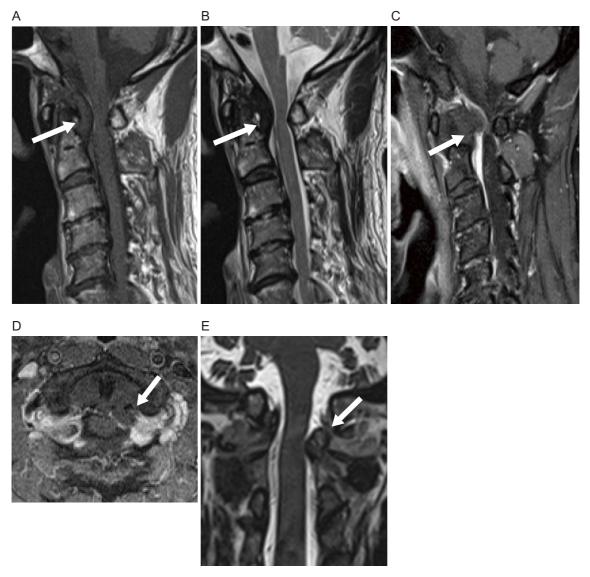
Preoperative magnetic resonance imaging. (A) Retro-odontoid pseudotumor is iso-intense on T1-weighted sagittal image (*arrow*), (B) Retro-odontoid pseudotumor is hypointense on T2-weighted sagittal image (*arrow*). (C) Retro-odontoid pseudotumor has rim enhancement on T1-weighted gadolinium-enhanced sagittal image (*arrow*). (D) T1-weighted gadolinium-enhanced axial image reveals the pseudotumor extending toward the left ventral aspect (*arrow*). (E) T2-weighted coronal image shows compression of the left nerve root of C2 by the pseudotumor (*arrow*).
